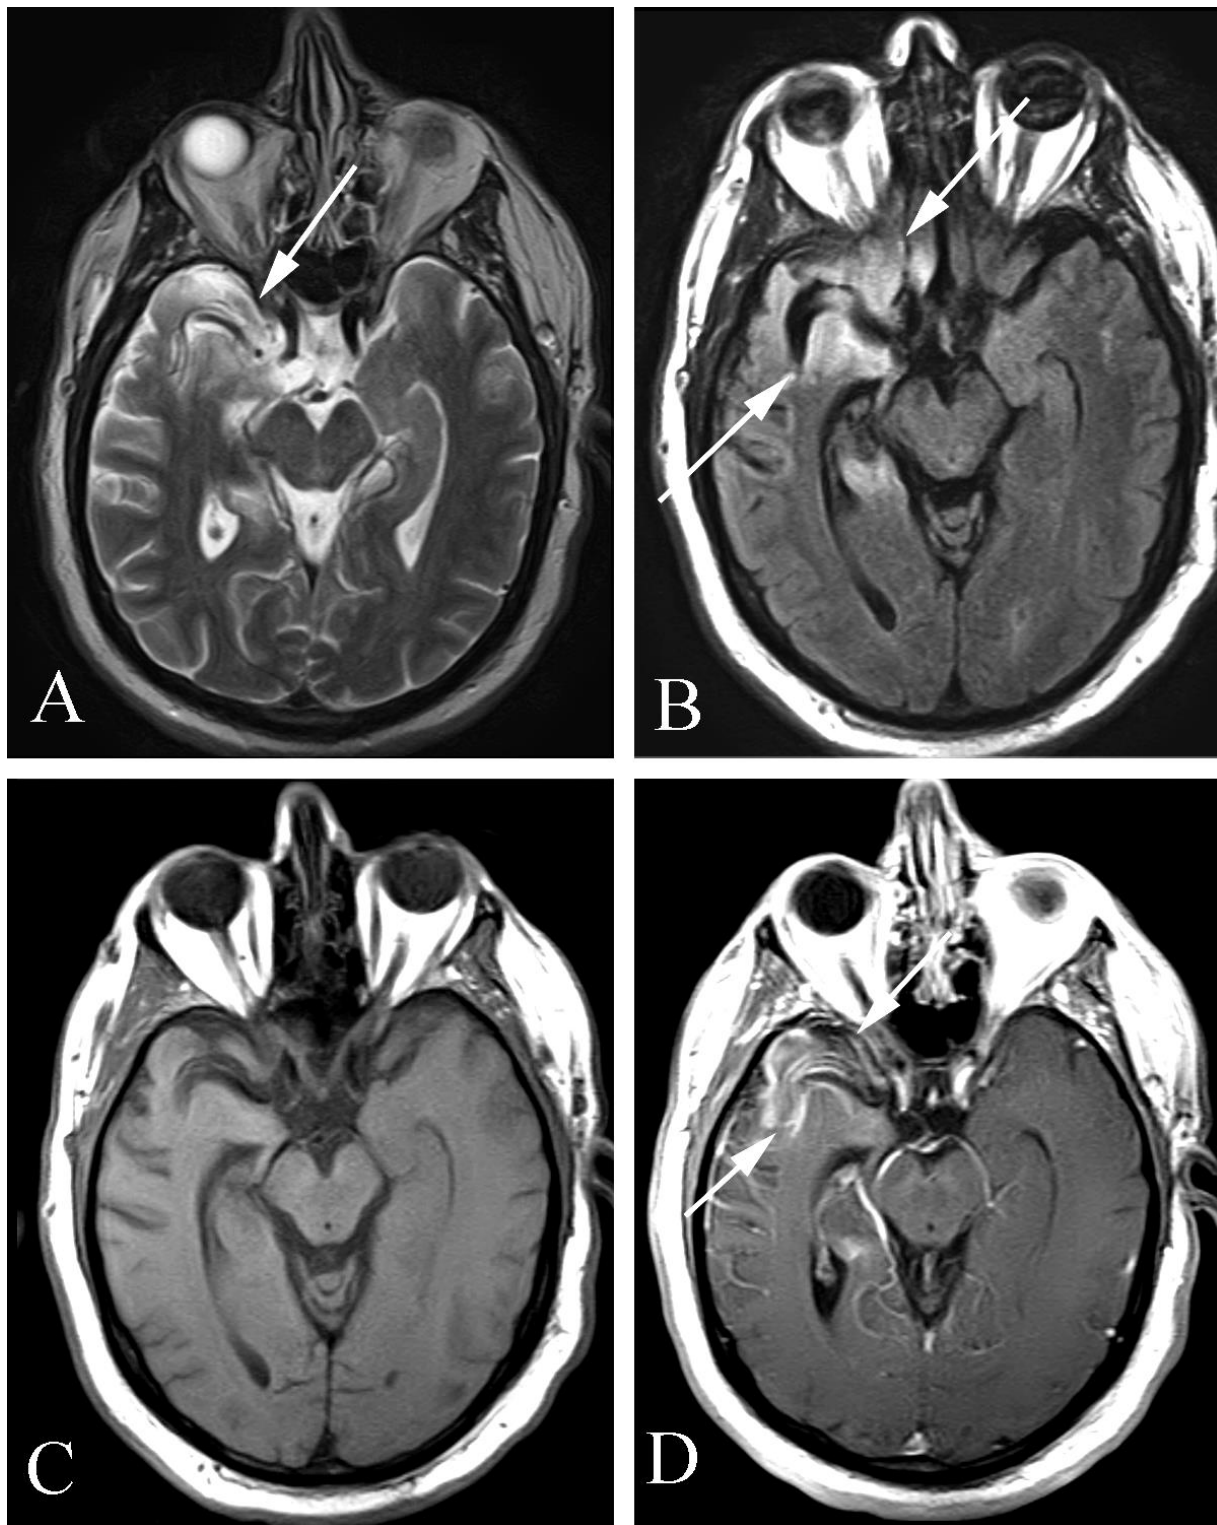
Herpes encephalitis in a 59 year old man with headache who also had fever. A. Axial T2 weighted MR image shows increased signal through the right temporal lobe (arrow). B. Axial FLAIR MR imaging also shows increased signal through the temporal lobe (arrows). C. Axial T1 weighted enhanced MR image shows accentuated sulci in the right temporal lobe. D. Axial T1 weighted postcontrast MR image demonstrates intense contrast enhancement of the abnormal brain parenchyma (arrows).
